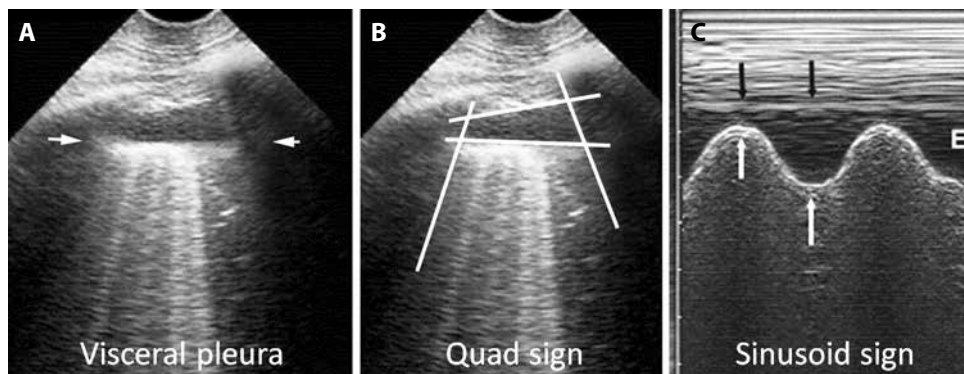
Examination of pleural effusions: quad and sinusoid sign; A — ultrasound examination of pleural effusion at the PLAPS point. Below the pleural line, a regular line roughly parallel to the pleural line can be seen: the lung line, indicating the visceral pleura (arrows); B — the visceral pleura (lung line), together with the parietal pleura (pleural line) and the shadow of the ribs, form a kind of quadrant: the quad sign; C — M-mode shows movement of the lung line or visceral pleura (white arrows) towards the pleural line or parietal pleura (black arrows) on inspiration, creating the sinusoid sign compatible with free pleural effusion. Quantitative data: this effusion found at the PLAPS point has an expiratory thickness of roughly 13 mm, i.e. an expectedly small volume. A 15-mm distance is the minimum required for safe diagnostic or therapeutic puncture [17]. E indicates expiration. Adapted from 'Lung ultrasound in the critically ill' [11]
